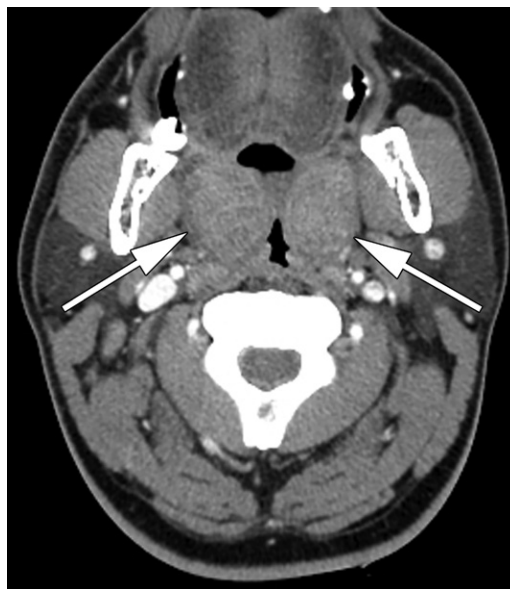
Tonsillitis in a 34-year-old man. Axial contrast-enhanced CT image shows enlarged palatine tonsils (arrows) that are in contact with each other ("kissing" tonsils) at the midline. The classic striated enhancement pattern is seen in the right tonsil.
